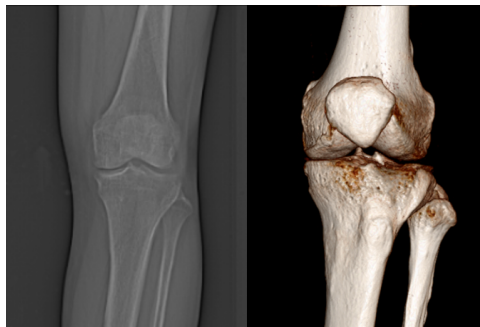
Topogram and VRT (Volume Rendering Technique) CT image of the female left knee joint CT images.
